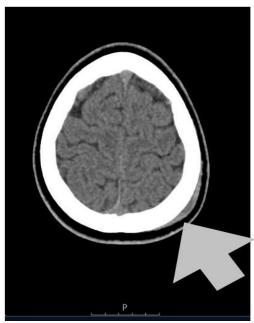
Computed tomography scan of the head (sagittal view) showing subgaleal haematoma (arrowed) in the left parietal region of male adolescent sickle cell anaemia patient.
